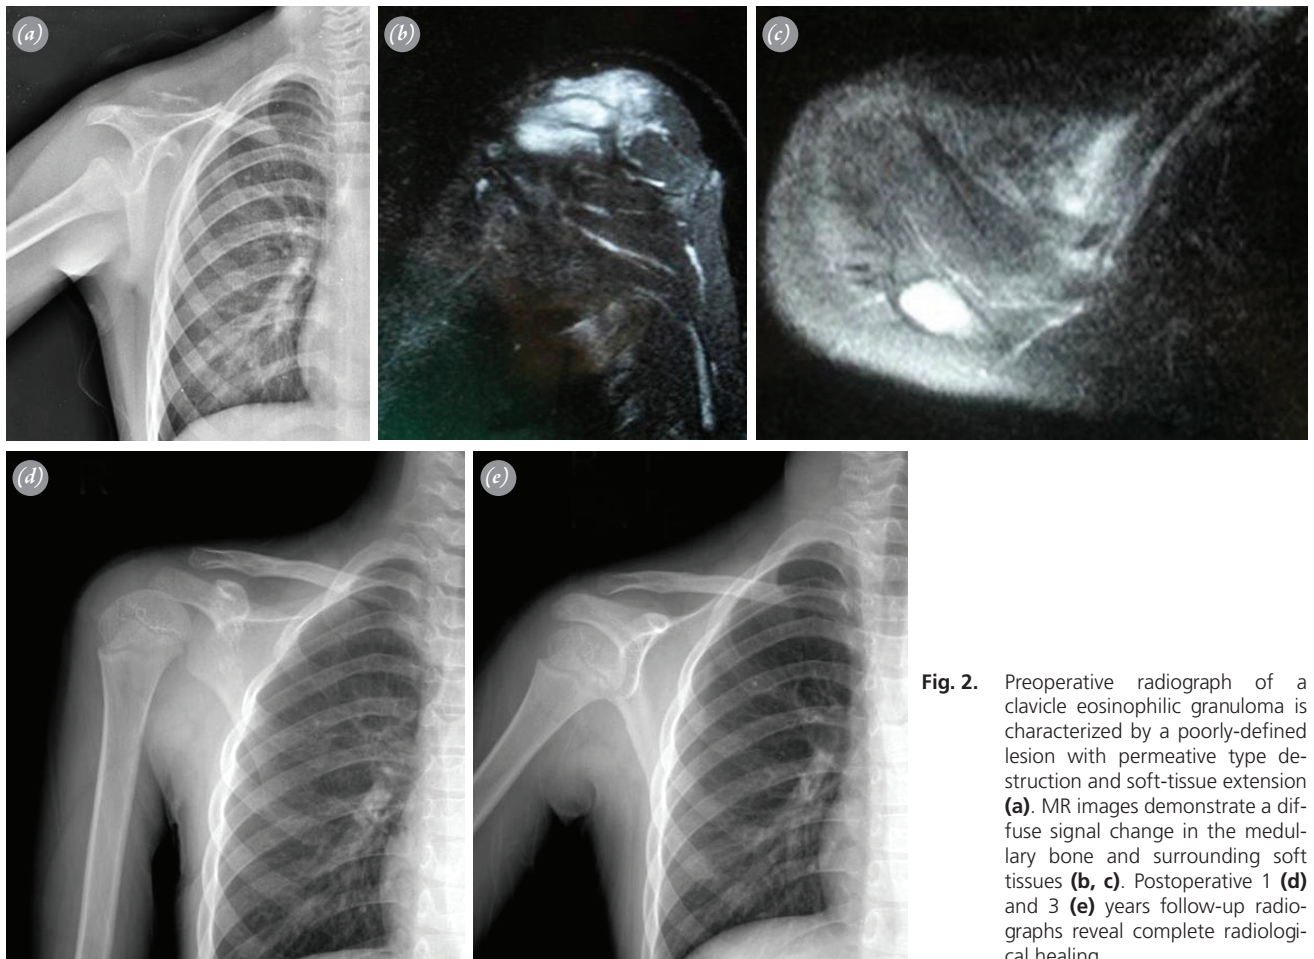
Preoperative radiograph of a clavicle eosinophilic granuloma is characterized by a poorly-defined lesion with permeative type destruction and soft-tissue extension (a). MR images demonstrate a diffuse signal change in the medullary bone and surrounding soft tissues (b, c). Postoperative 1 (d) and 3 (e) years follow-up radiographs reveal complete radiological healing.
